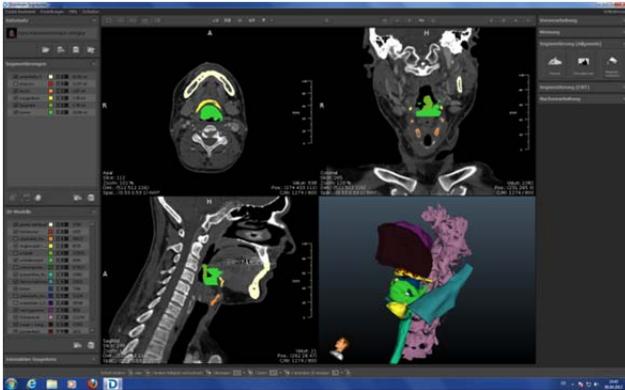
Screenshot of the CT-data segmentation process using Dornheim Segementer software including a 3-D reconstruction of the segmented structures
